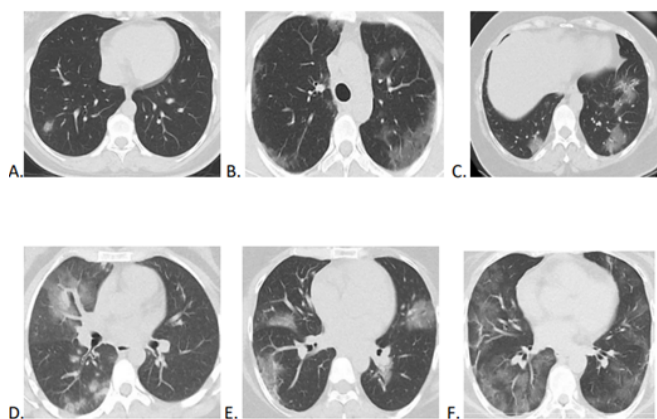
Examples of CT-SS calculated on CT sections of some patients. A) CT-SS is 1 points; for area of radiologic involvement <5% in the right lung. B) CT-SS is 4 points; 2 points for radiologic involvement of 5-25% in each lung. C) CT-SS is 4 points; 1 points for area of radiologic involvement <5% in the right lung and 3 points for radiologic involvement of 26-49% in the left lung. D) CT-SS is 5 points; 4 points for radiologic involvement of 50-75% in the right lung and 1 point for radiologic involvement in the left lung. E) CT-SS is 5 points; 3 points for radiologic involvement of 26-49% in the right lung and 2 points for radiologic involvement of 5-25% in the left lung. F) CT-SS is 10 points; 5 points for radiologic involvement >75% in each lung. CT-SS: computed tomography severity score
